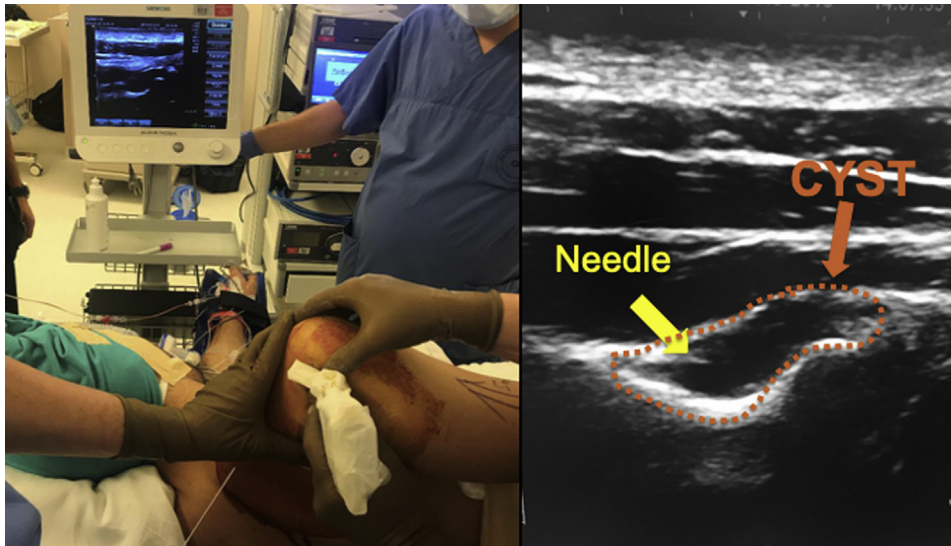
View of the right shoulder with the patient in lateral decubitus position. Note the introduction of the needle to the spinoglenoid notch ganglion cyst under real-time imaging ultrasound guidance.
